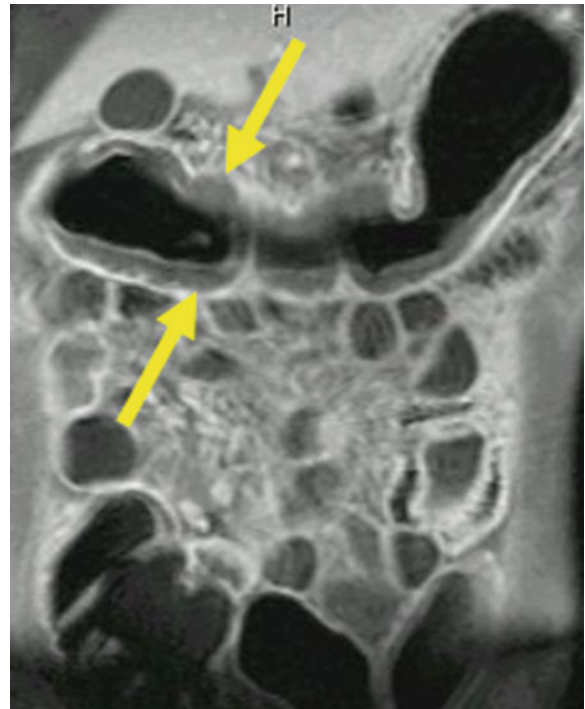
Dark-Lumen MRC: Coronal T1-weighted SPGR post IV contrast shows moderate thickening and enhancement of the wall of the transverse colon in patient with ulcerative colitis (Courtesy of Andrea Laghi, MD, University of Rome, Latina, Italy)
